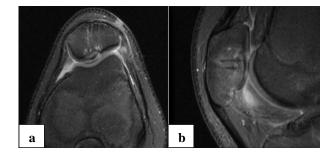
MRI at 3-month showing fragment incorporation.
